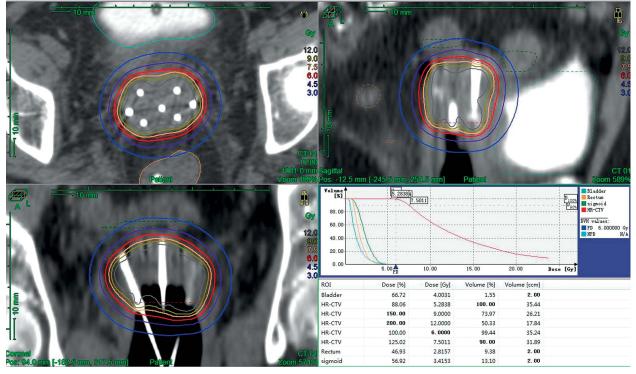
Representative treatment planning of interstitial brachytherapy, guided by computed tomography, for recurrent cervical cancer. A dose of 6 Gy was prescribed for high-risk clinical target volume (HR-CTV) by using seven interstitial metal needles inserted to the recurrent tumor
